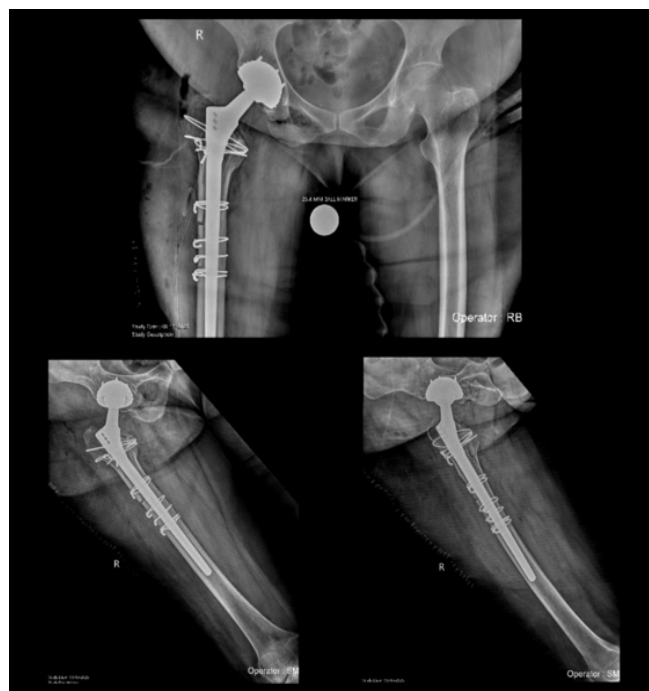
Post-operative radiographs in anteroposterior and lateral views of the right hip taken after weight bearing. A stable diaphyseal stem is seen with cerclage wires of the greater trochanter, with 3 cerclage wires over the cortical window and one cerclage wire above the window. An uncemented dual mobility cup and head are also seen.
